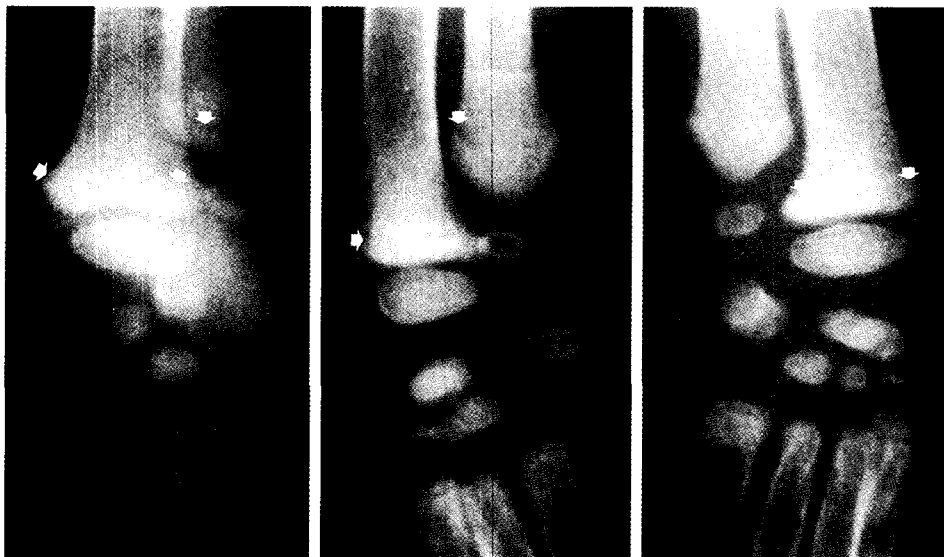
Craniocaudal (a) and oblique (b) radiographic views of the left carpus, and craniocaudal radiograph of the right carpus (c). Irregular radiolucent zones are seen in the radial and ulnar metaphysis (arrows), proximal to the physis, and there are regions of increased opacity proximal to the lucent zones (open arrows).
